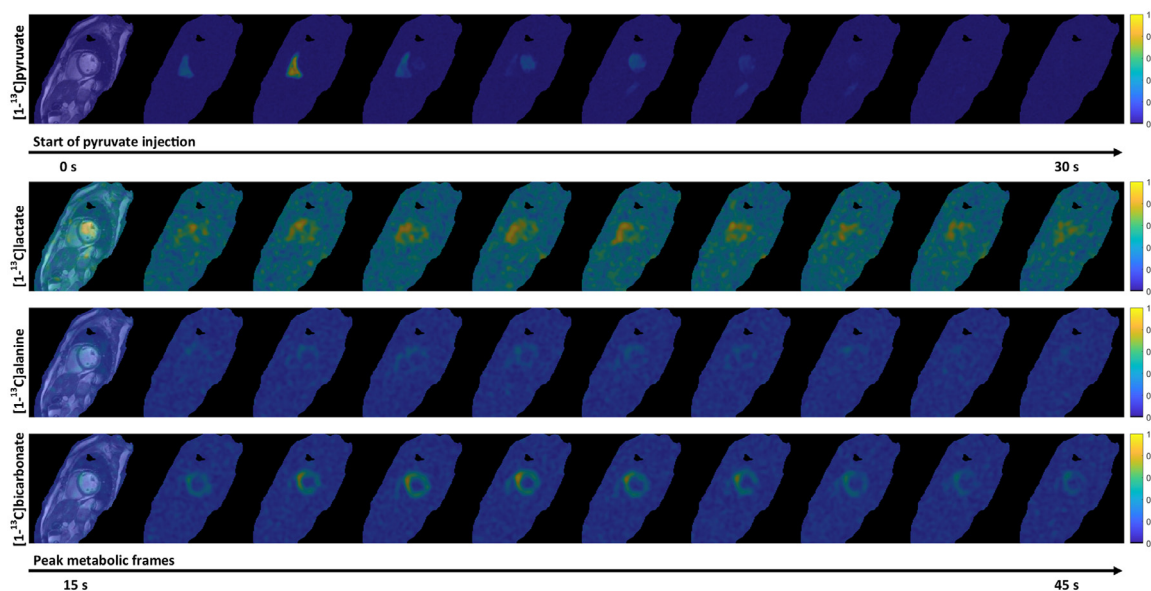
An example of a patient with chronic heart failure and left ventricular ejection fraction of 30%. Images shows temporal dynamics of pyruvate, lactate, alanine, and bicarbonate in a single slice at the mid left ventricular level. The left image shows the ^1H MRI image for anatomical reference. The right-side color scale (0-1) shows the relative signal from each metabolite. Subsequently, the left ventricular myocardium can be divided into subsegments and analyses of e.g., metabolite ratios or k_{PL} and k_{PB} can be done to assess regional differences in myocardial metabolism. (Data from own experiments at the MR-Research Centre, Aarhus University Hospital).
